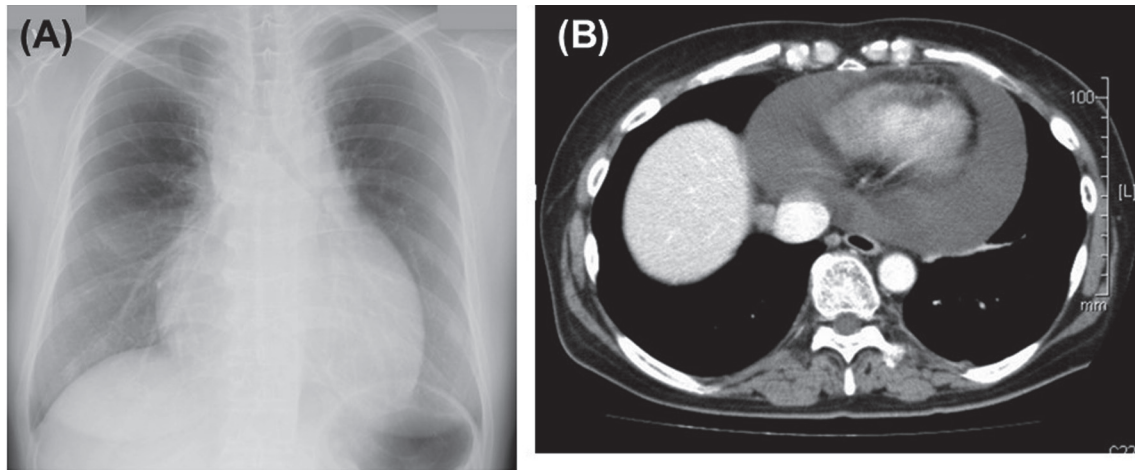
Chest radiograph showing an enlarged heart caused by pericardial effusion at the time of admission. (A) Chest radiograph; (B) Computed tomography scan.
